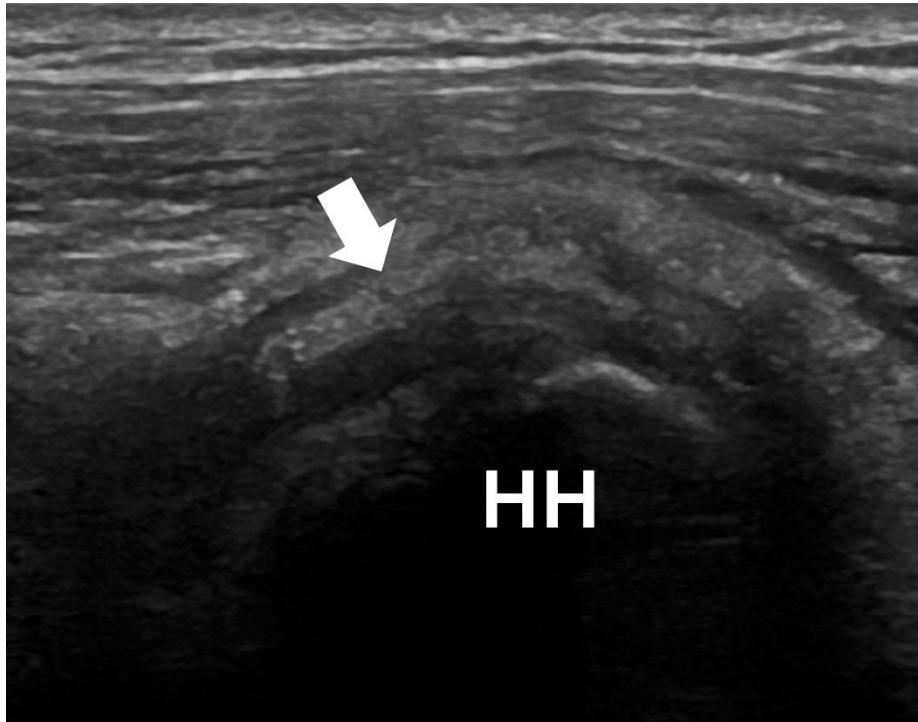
Ultrasound longitudinal view of the supraspinatus tendon demonstrating a highly echogenic intratendinous lesion with posterior acoustic shadowing.
